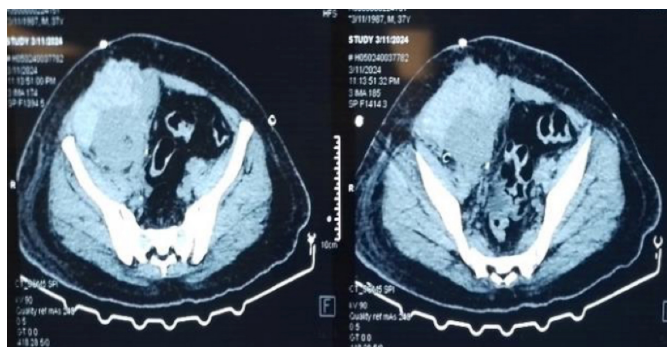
CT scan of abdomen and pelvis showing perigraft collection.
